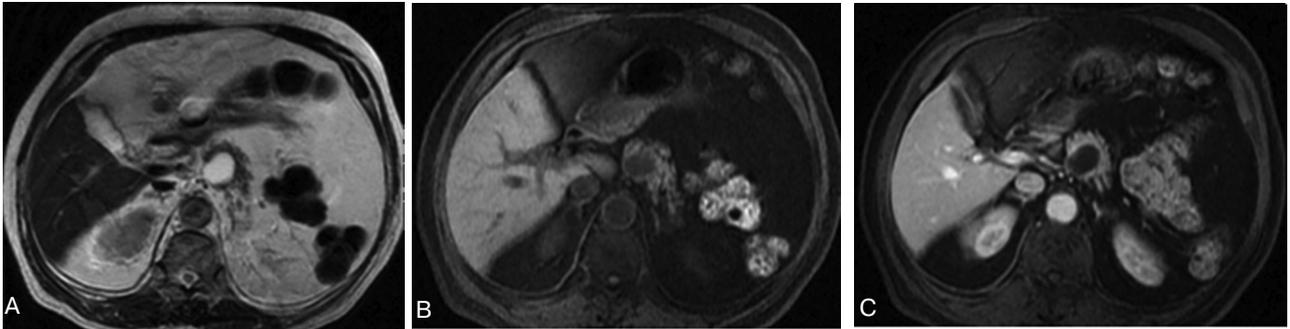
MRI of pancreatic pseudocyst. A. Axial T2-weighted MR image shows unilocular hyperintense cystic lesion located between pancreas and aorta. B. Axial T1-weighted MR image presents the hypointense lesion. C. On axial contrast-enhanced T1-weighted MR image the lesion shows no gadolinium uptake
